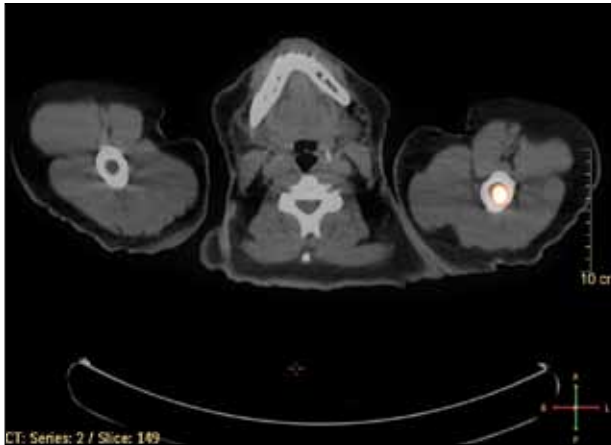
A focus of increased radiotracer deposition is seen in the left proximal humerus on positron emission tomography–computed tomography scanning.
